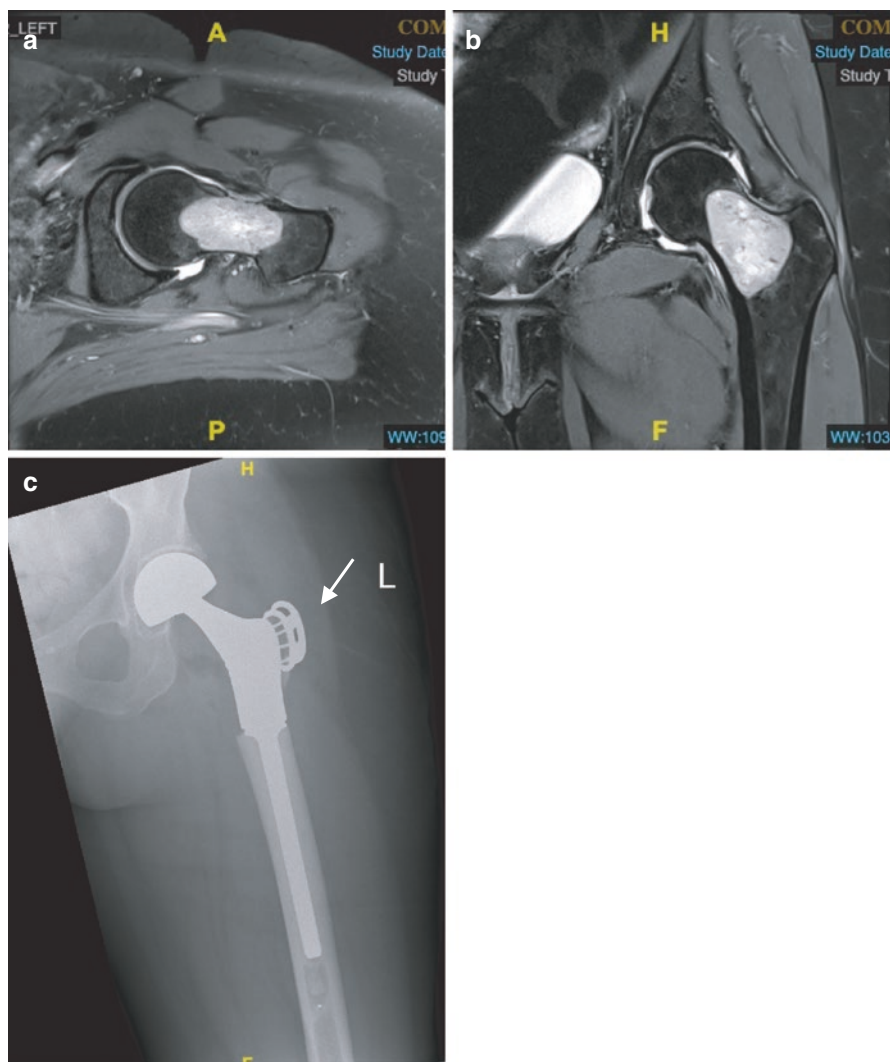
Proton density fat-saturated (a) axial and (b) coronal MRI images of proximal femoral tumour. (c) Sliver of greater trochanter with attached gluteus medius was preserved and reattached to the proximal femoral tumour endoprosthesis (arrow)
